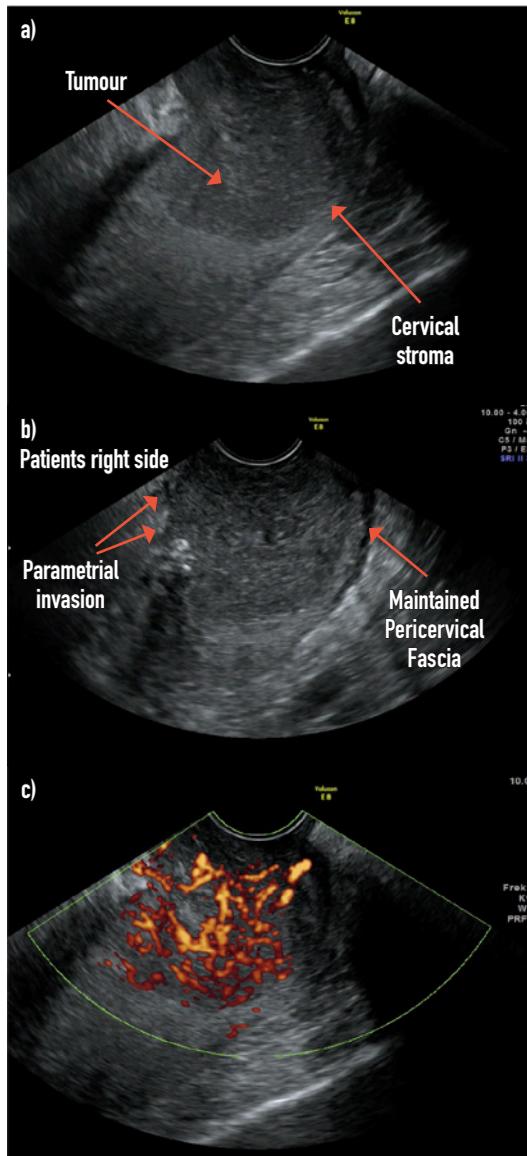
A 63 years old woman with cervical cancer, stage IIB. 6a: US grayscale image in sagittal plane showing hypoechoic tumour filling out almost the whole cervix with minimal cervical stroma seen on the back side 6b: Transverse section of the same tumour showing parametrial invasion on the patients right side but maintained paracervical fascia on the patients left side (arrow) (arrow). 6c: 2D power Doppler in sagittal plane, abundant vascularization the indicates invasion anteriorly towards the bladder.
